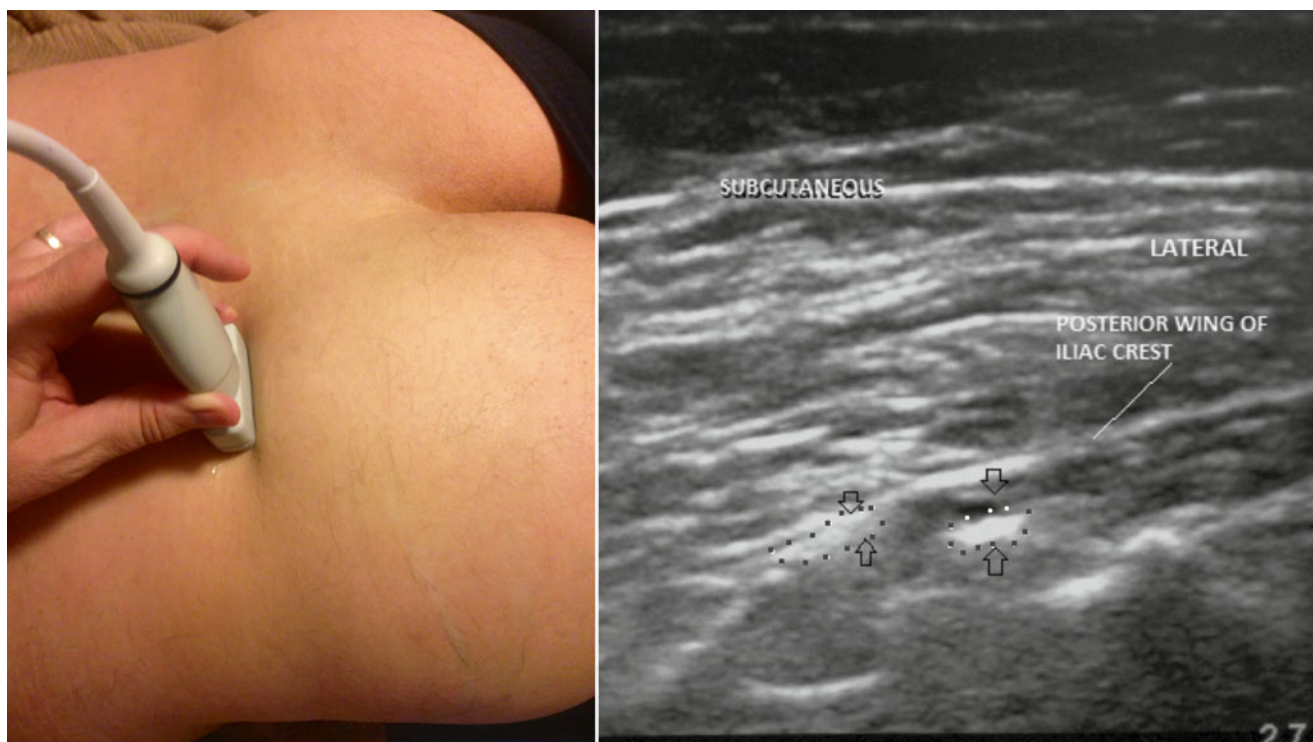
Ultrasound image of the superior cluneal nerve. *Arrows and outline* = superior cluneal nerves (Image courtesy of Terri Dallas-Prunskis, MD)
